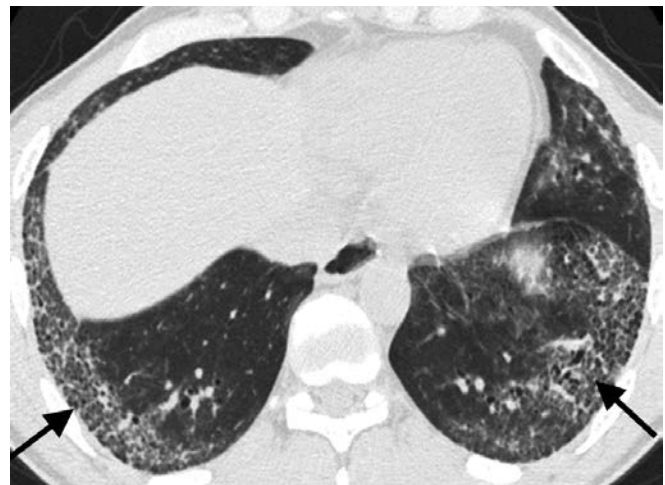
HRCT through the lung bases showing subpleural reticulation in a patient with idiopathic pulmonary fibrosis. Also visible are small cysts (arrows) from honeycombing
